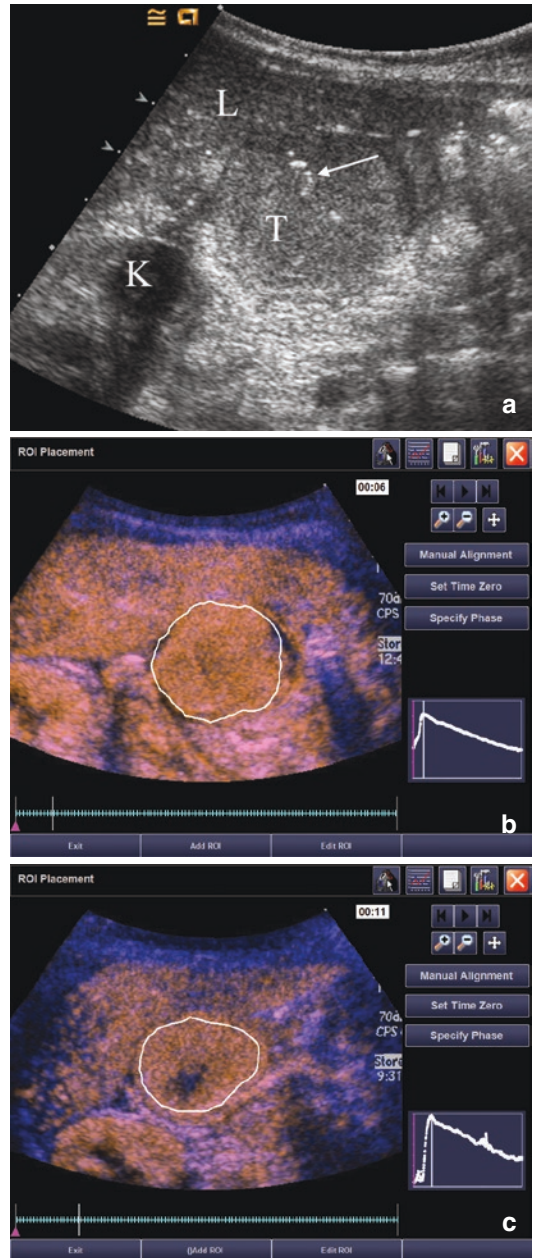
A 21-month-old girl with recurrent rhabdoid tumor. (a) Transverse grayscale sonogram shows a peritoneal tumor (T) located posterior to the liver (L) and medial to the right kidney (K). Tumoral calcification (arrow) and adjacent organs were used as landmarks for transducer placement. (b) Baseline CEUS image with ROI inside tumor margins, obtained at PE of 33.5 dB. (c) Day 7 after initiation of therapy, CEUS image obtained at PE of 30.6 dB giving an 8.7% reduction compared to baseline. This subject progressed at 22 days after initiation of therapy (reprinted with permission from reference [67])
